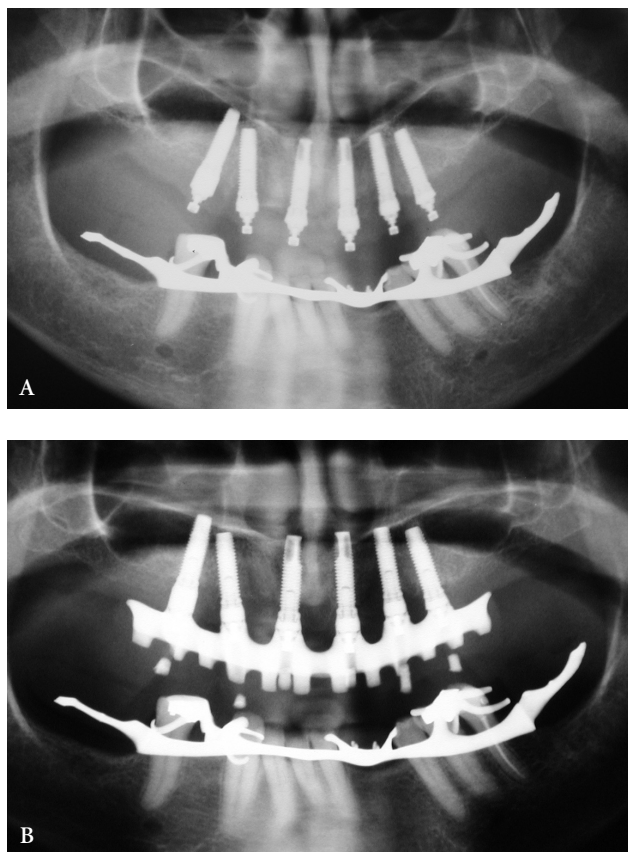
A, Radiograph taken after implant placement; B, radiograph showing extent of permanent bridge.
